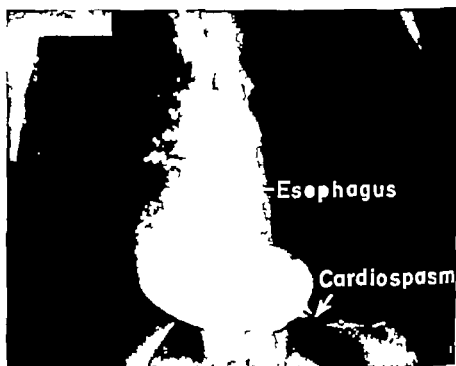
Roentgenogram revealing a typical cardiospasm (achalasia). The nonorganic obstructed area is located at the distal end of the esophagus and proximal to this is the dilated and tortuous esophagus.
